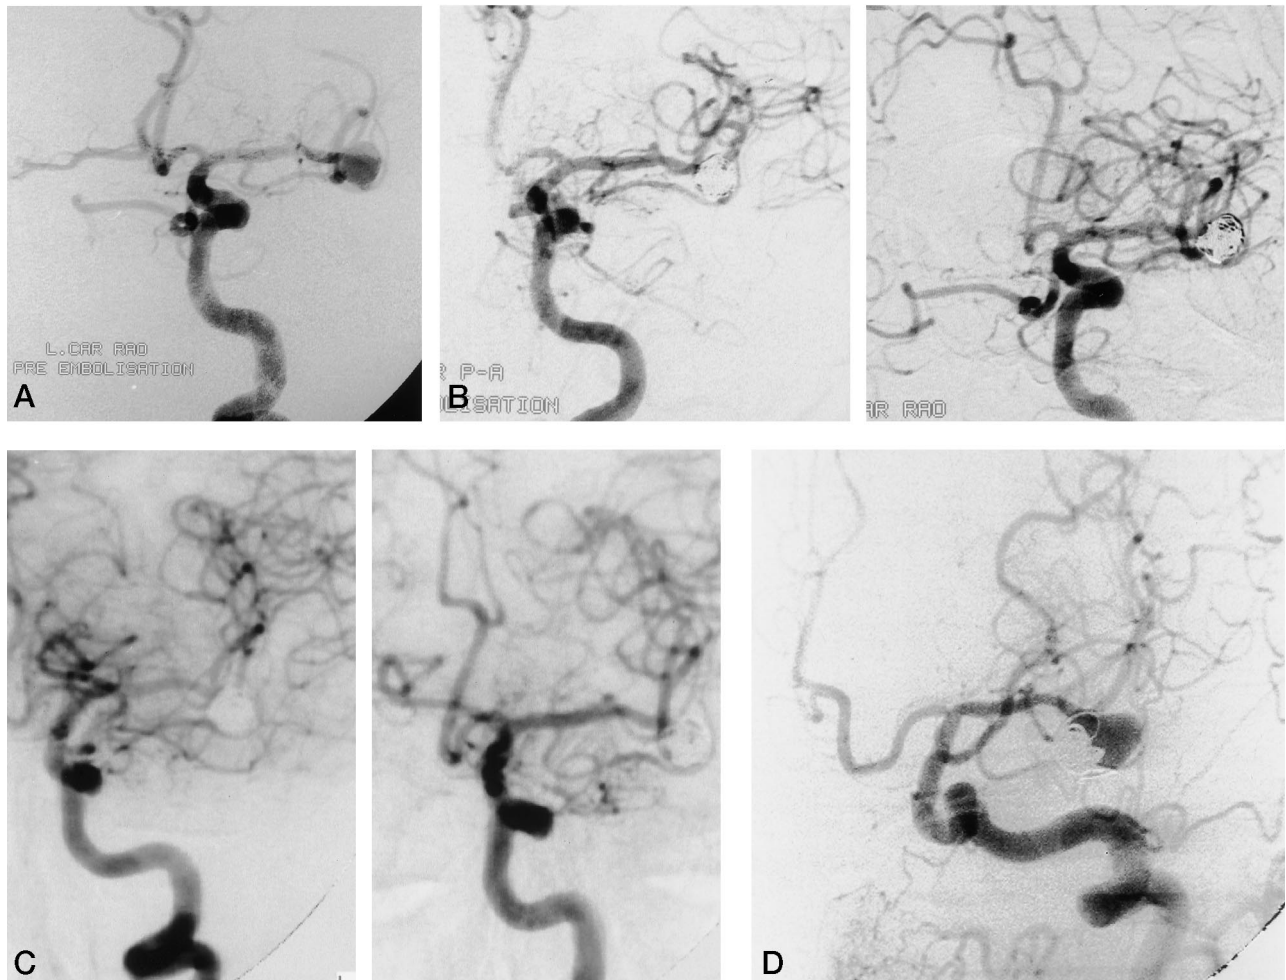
55-year-old woman with CT findings of a probable aneurysm in the region of the left middle cerebral artery bifurcation.
